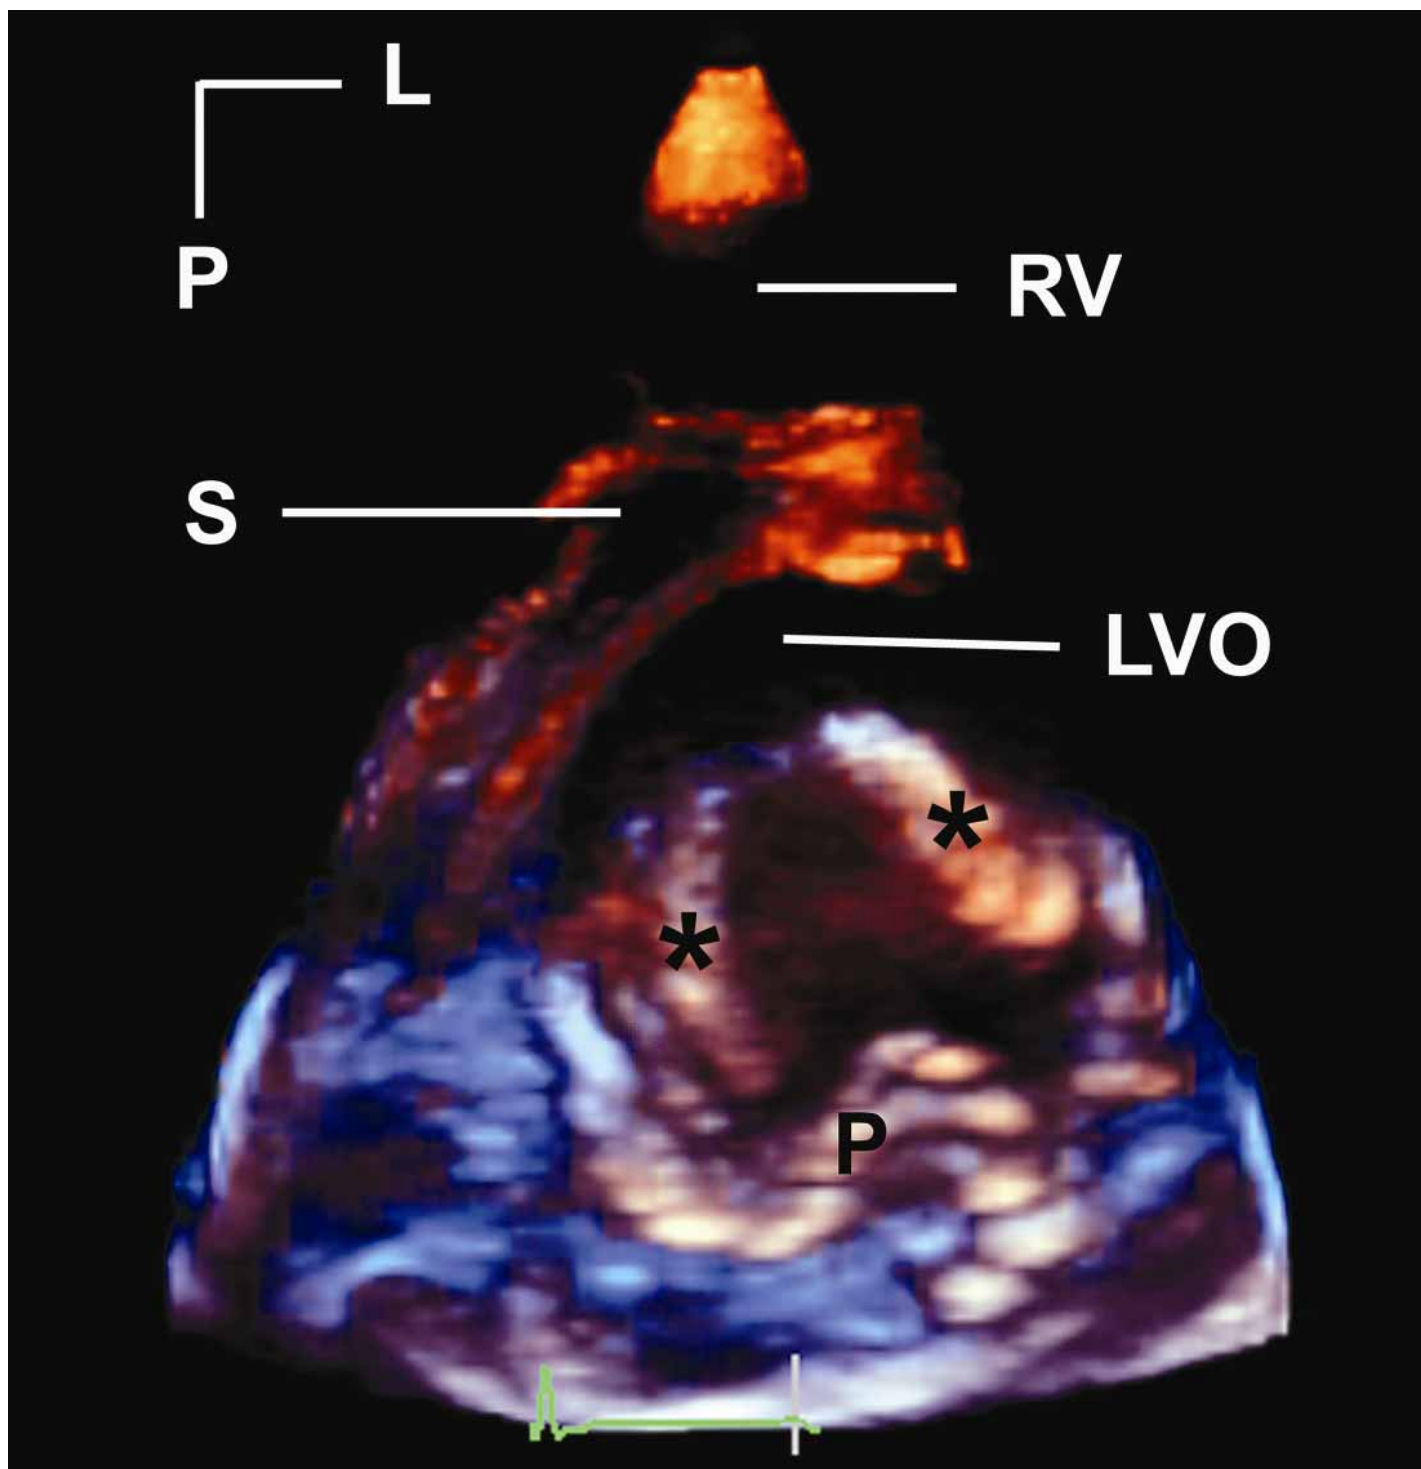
Parasternal short axis view of an isolated cleft of the anterior mitral leaflet. The two edges of the cleft are marked by asterisks. The posterior mitral leaflet has a prominent middle scallop (P). L, left; LVO, left ventricular outflow; P, posterior; RV, right ventricle; S, septum.
